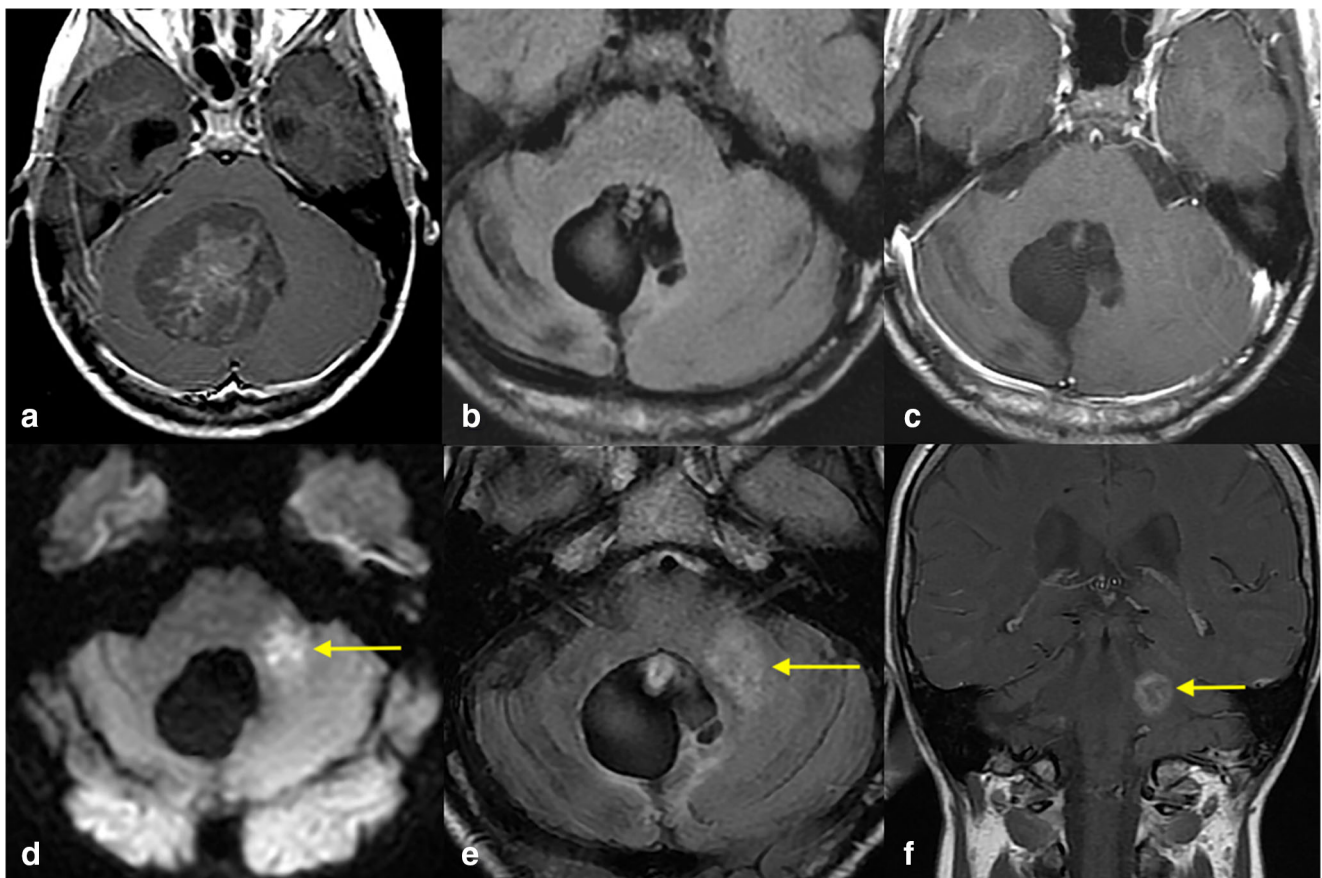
Case 3. MRI images for case 3; (a) axial post-contrast T1W depict the heterogeneously enhancing original tumor in the fourth ventricle; (b) axial FLAIR and (c) post-contrast T1W show post-operative total resection of the tumor with post-surgical distortion of the fourth ventricle.
